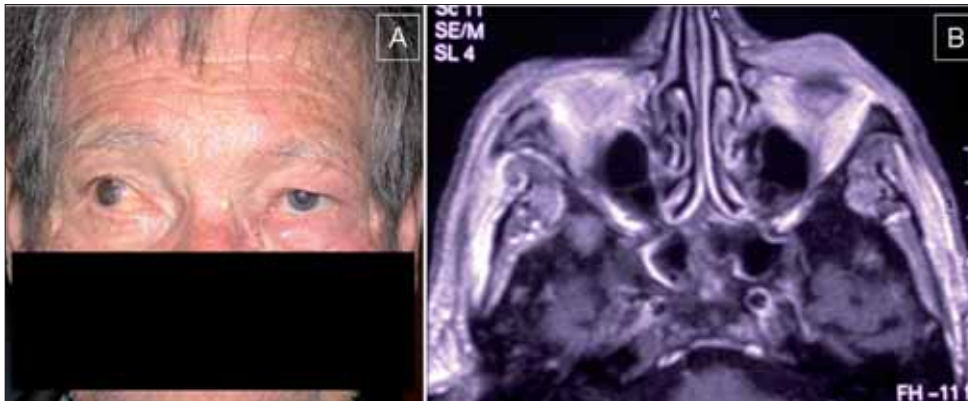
Subcutaneous mass under the inferior left eyelid. Post-traumatic microphthalmos in right eye and enophthalmos in left eye (A). MRI scan shows a subcutaneous mass (20 x10 mm) in correspondence of the left inferior eyelid and an initial infiltration of the adipose tissue of the inferolateral sector, with mild enophthalmos (B).
